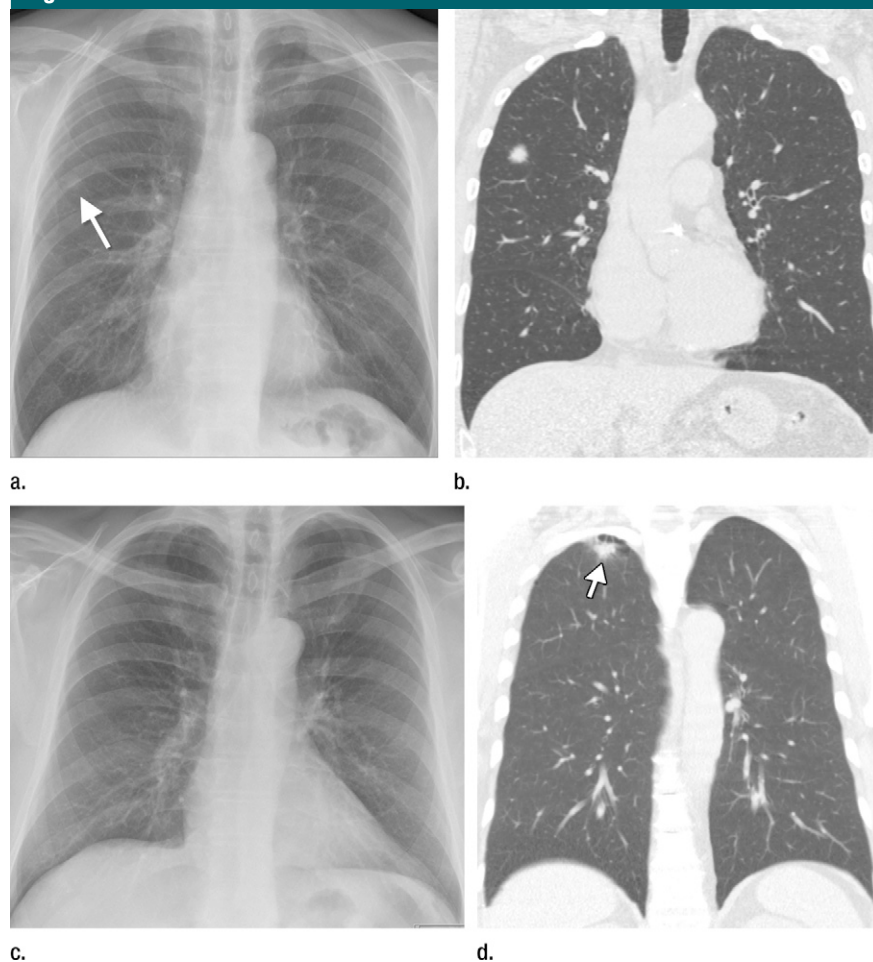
(a, b) Small 11.4-mm-diameter malignancy that was correctly localized and scored as definitely present by all observers (arrow) at (a) digital chest radiography and (b) CT. (c) Digital chest radiograph and (d) CT scan of malignancy (arrow) that was not detected by any of the observers during the study or retrospectively with knowledge of CT findings.
